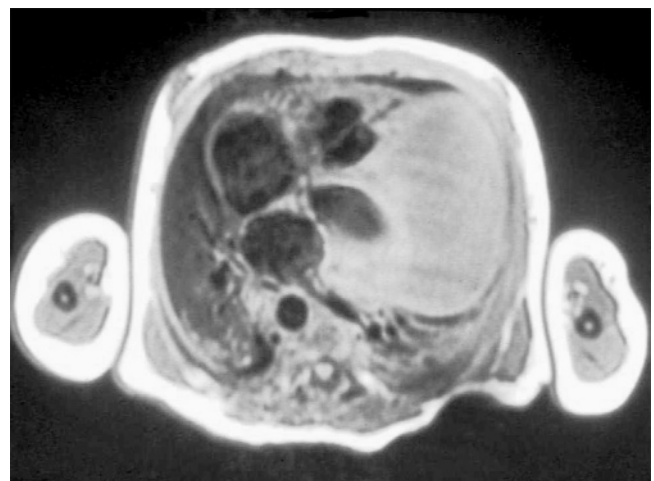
Magnetic resonance image showing a massive cardiac rhabdomyoma diffusely infiltrating both ventricles. The patient was born with fetal hydrops but now has normal cardiac function.
